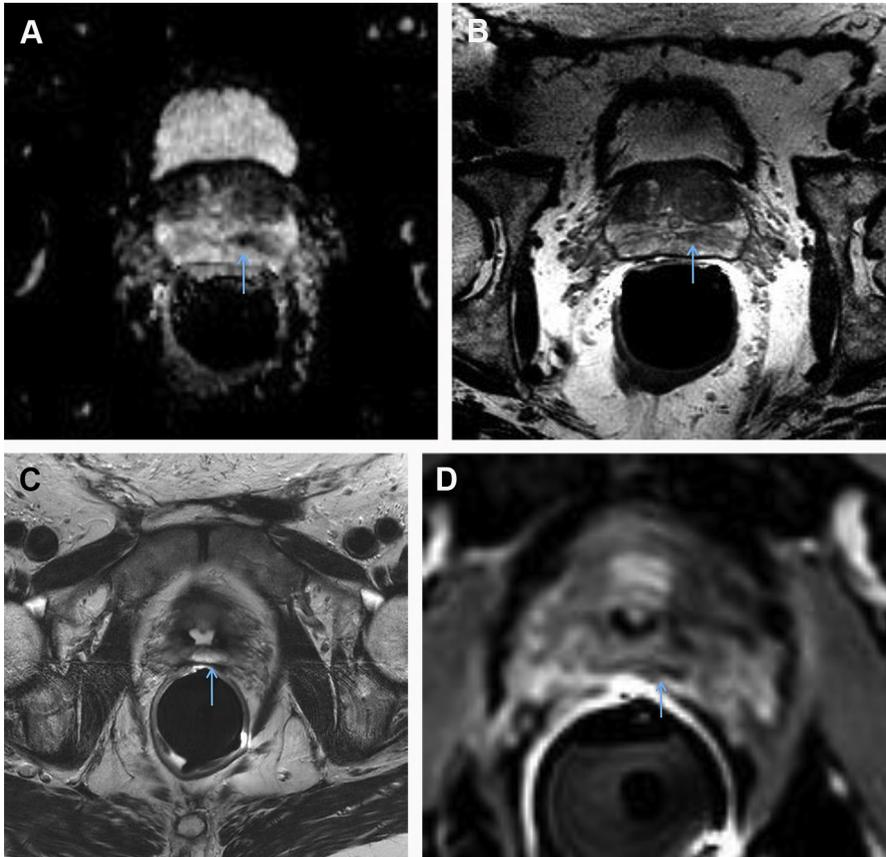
HIFU treatment. MR imaging of a 61-year-old patient pre-HIFU and post-HIFU treatment of a left-sided Gleason 6 prostate cancer located in the peripheral zone of the medial left midgland/base (arrows). (A) The peripheral zone cancerous focus in the left midgland/base demonstrates low ADC signal on pretherapy imaging. (B) The lesion shows corresponding T2 hypointense signal. (C) After HIFU therapy, focal cystic change is seen in the medial left midgland/base, including at site of preexisting cancerous lesion. (D) On post-treatment contrast-enhanced MR imaging, there is localized nonenhancement in the region of the patient's original left-sided prostate cancer.
